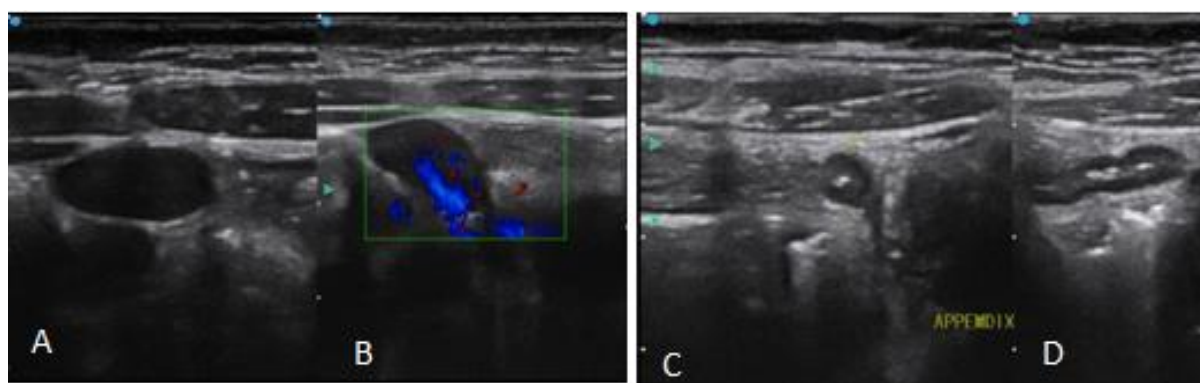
US images in a 7 year old who presented with a 1 day history of RIF pain. A and B show mesenteric enlarged lymph nodes with central flow on colour Doppler C and D show a normal appendix in the same patient
